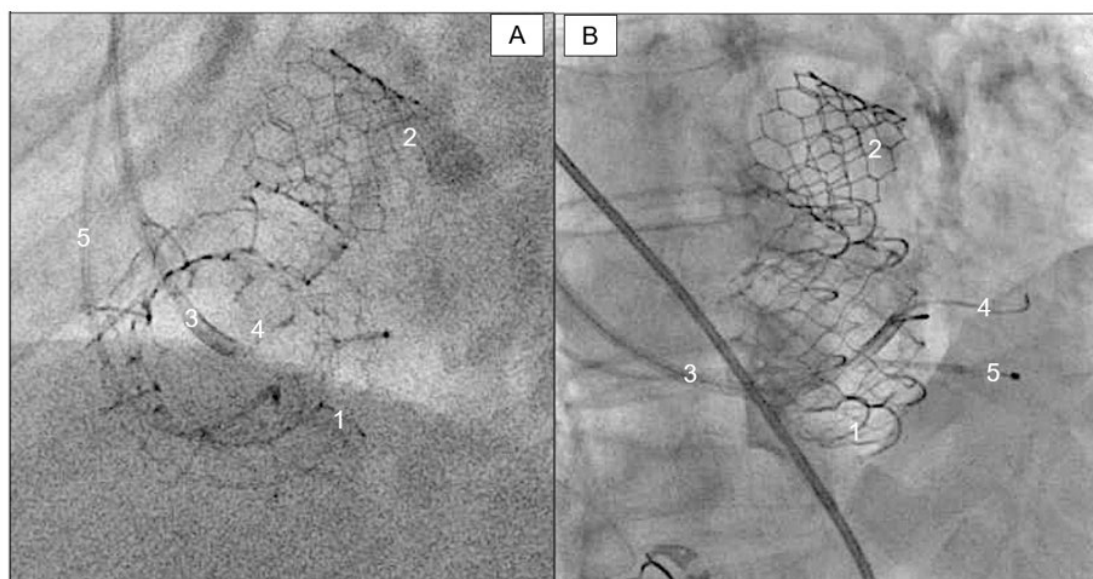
Peri-interventional X-ray images in LAO 40° (depicted in A) and RAO 30° (depicted in B). 1 = tricuspid valve prosthesis, 2 = aortic valve prosthesis, 3 = conduction system pacing sheath, 4 = guide wire, 5 = temporary pacemaker lead.
